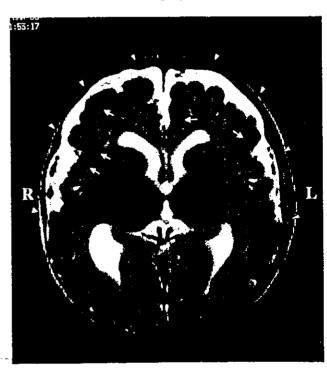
An axial MRI [T2-weighted image: TR = 3100 ms, TE = 95 ms] of case 2 shows the irregularities of the gray-white matter junction (arrows) in the bilateral frontal-temporal-perisylvian regions at 3 months of age. The irregularities of the gray-white matter junction are seen more clearly in the right side. Note abnormal patterns of the gyri (arrowheads). The bilateral occipital regions look relatively normal.
